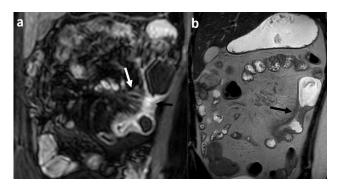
A 17-year-old boy with known Crohn's disease. Coronal contrast-enhanced T1-weighted with fat suppression image (a) and coronal SSTSE T2-weighted image (b) show focal wall thickening in the small bowel loop and stricture (black arrow). The bowel proximal to the stricture is dilated. The white arrow shows the ectasia of the vasa recta with the characteristic "comb sign". Mesenteric fibrofatty proliferation is seen in figure (b).
